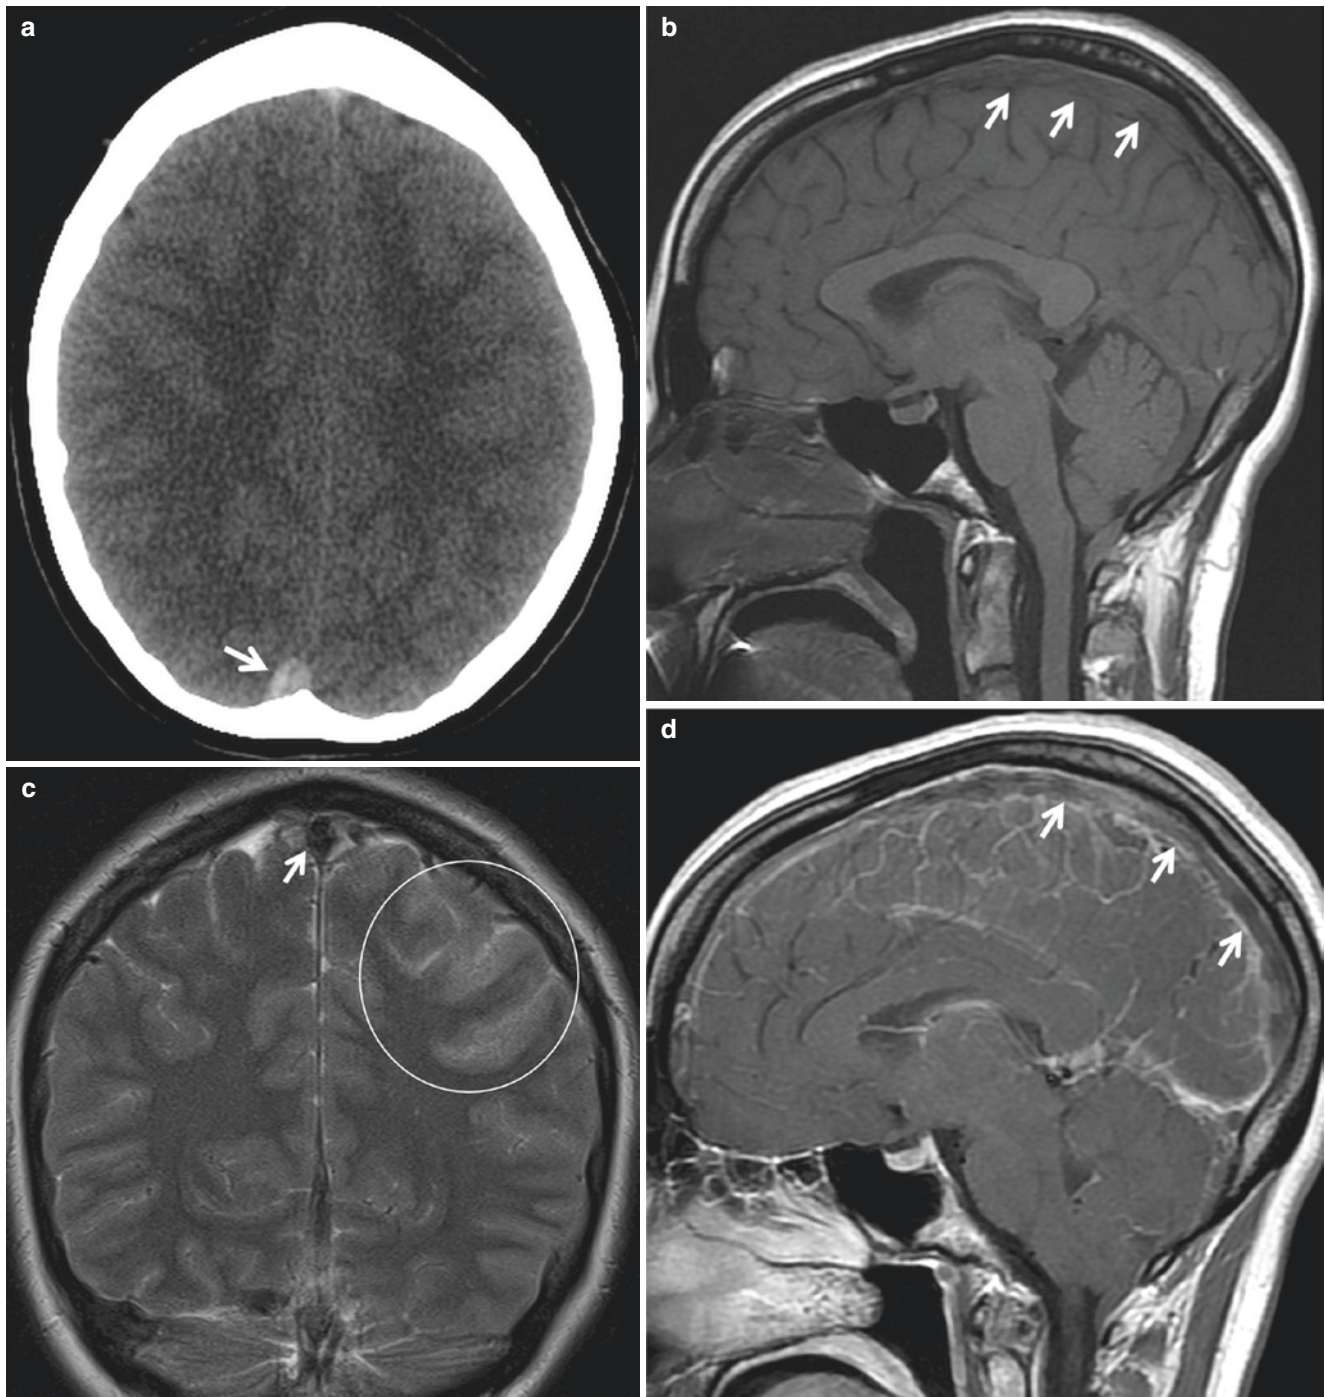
Acute dural sinus thrombosis. A 26-year-old woman with headache for a few days and seizure. (a) Axial NCCT demonstrates hyperdensity of the superior sagittal sinus (SSS) suggestive of thrombosis. There is diffuse cerebral sulcal effacement but without hemorrhage or large infarction. (b–e) MRI of the brain shows isointensity on sagittal T1 (b) and hypointensity on coronal T2 (c) in the SSS, reflecting deoxyhemoglobin in the acute stage of thrombosis (arrows). There is mild cortical/subcortical edema in the left frontoparietal junction on the coronal T2 image (circle in c). (d) Sagittal
